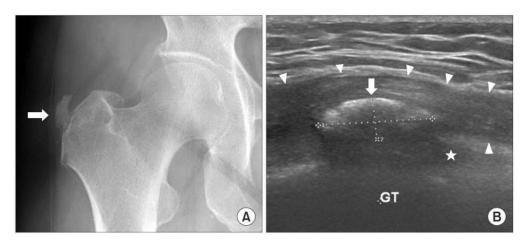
(A) An anteroposterior radiograph of the right hip showing an amorphous calcification (white arrow) adjacent to the greater trochanter. (B) Ultrasonography of the right hip showing a solid calcific nodule (white arrow) at 2.0 $cm \times 0.7$ cm in size adjacent to the insertion site of the gluteus medius tendon (asterisk) between the greater trochanter (GT) and the iliotibial band (arrowheads). Retrieved from: Jo H, Kim G, Baek S, Park HW. Calcific Tendinopathy of the Gluteus Medius Mimicking Lumbar Radicular Pain Successfully Treated With Barbotage: A Case Report. Ann Rehabil Med. 2016 Apr;40(2):368-72.
